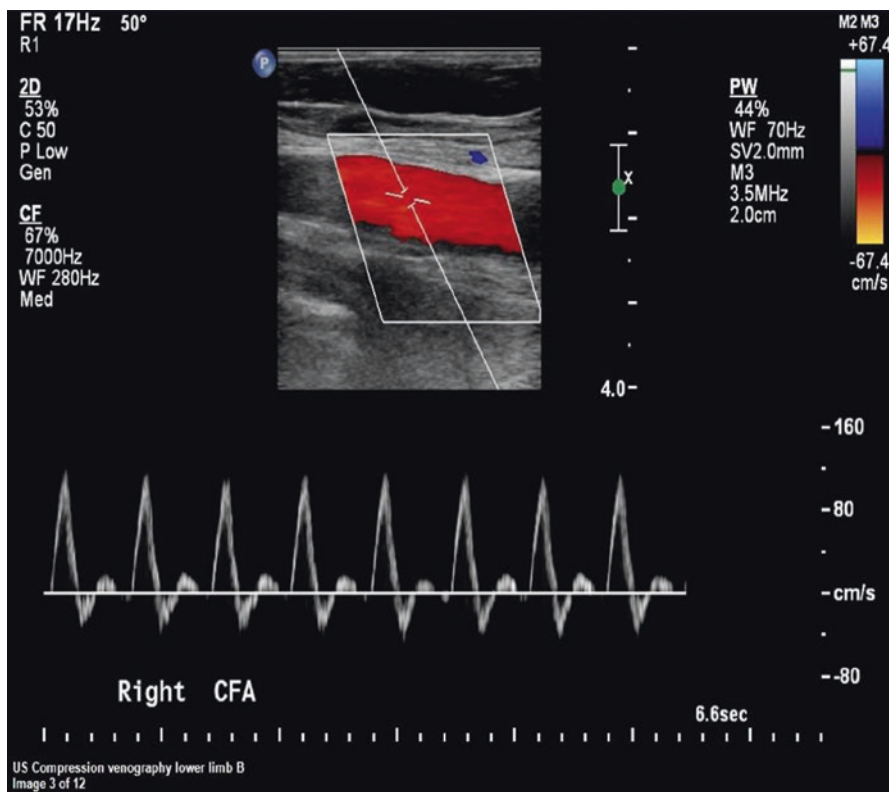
Doppler spectrum normal appearances of a peripheral artery showing colour flow and spectral Doppler information with its characteristic triphasic Doppler waveform
